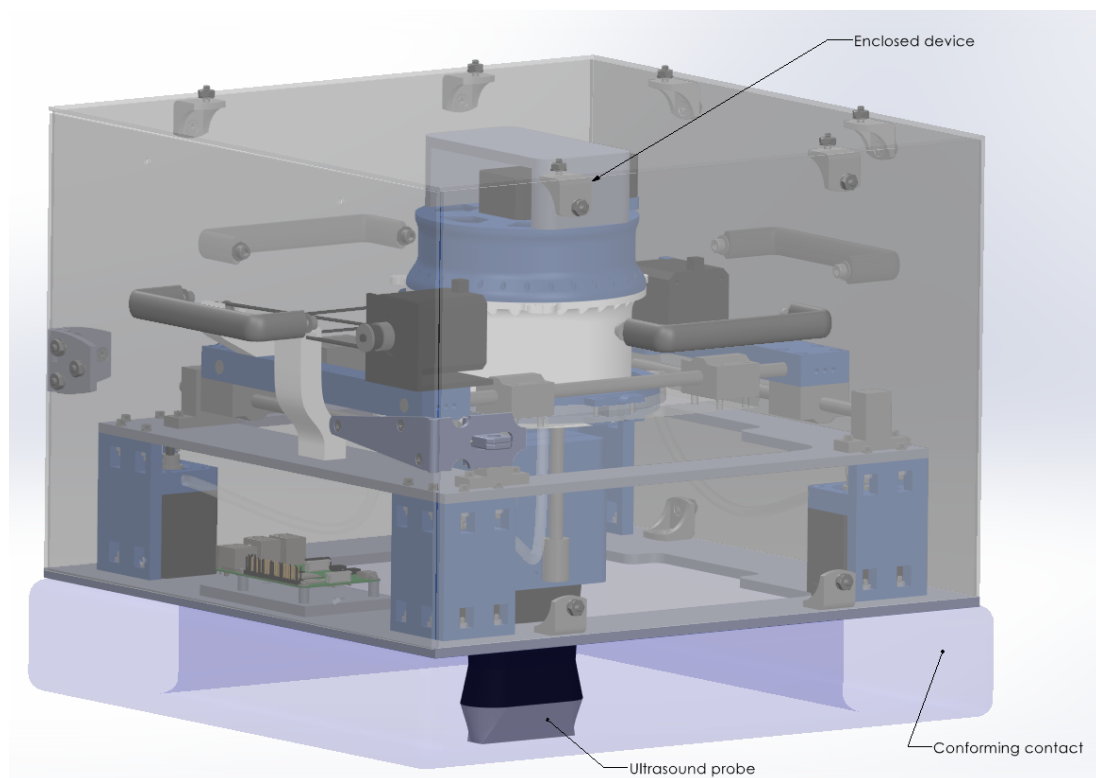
Figure A-2: Teleoperated Ultrasound Device
